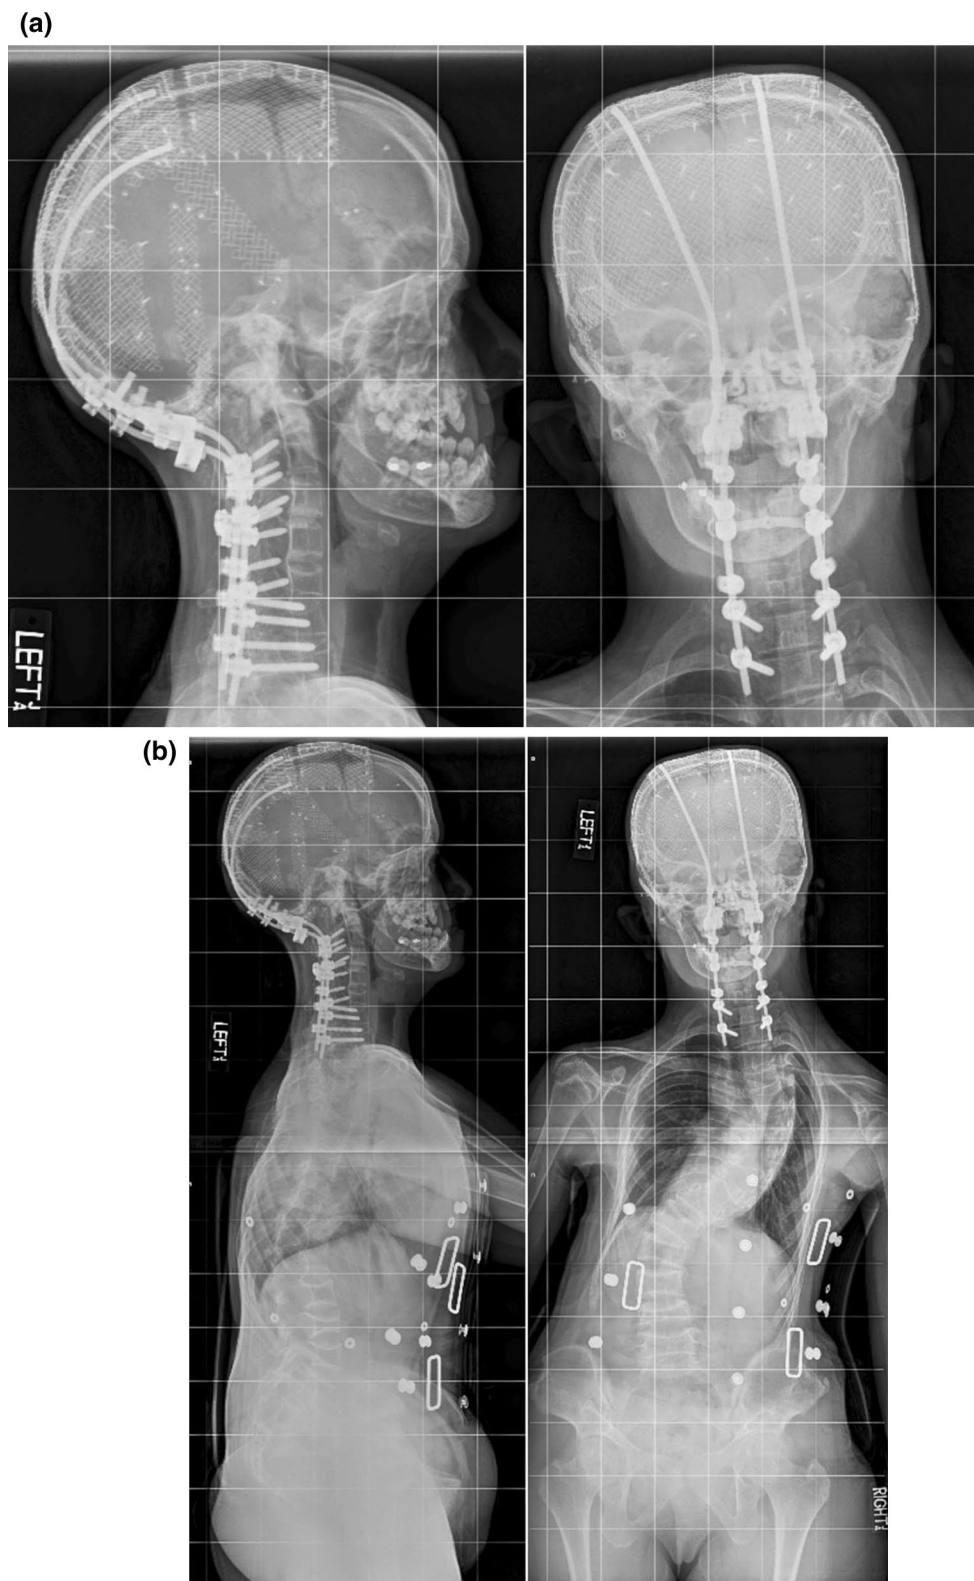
Standing AP and lateral radiographs of the cervical spine and skull (a) and entire spine (b) at 18 months from the revision surgery show intact hardware and satisfactory alignment of the instrumented region
